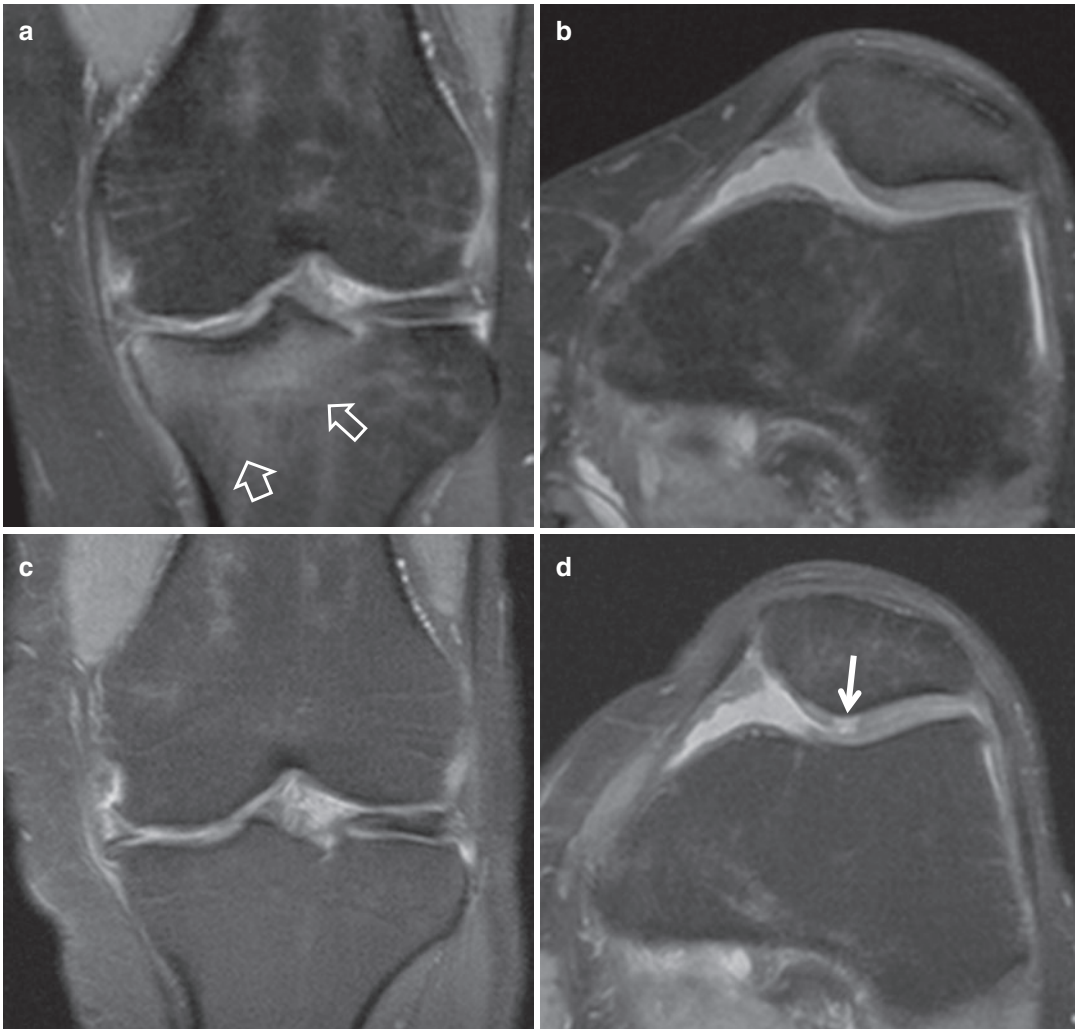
(a–d) Resolution pattern of bone bruise in a 26-year-old male mountain skiing athlete, with lateral patella dislocation prior to imaging. (a) Coronal and (b) sagittal fat-suppressed PD-w MR images of the right knee
